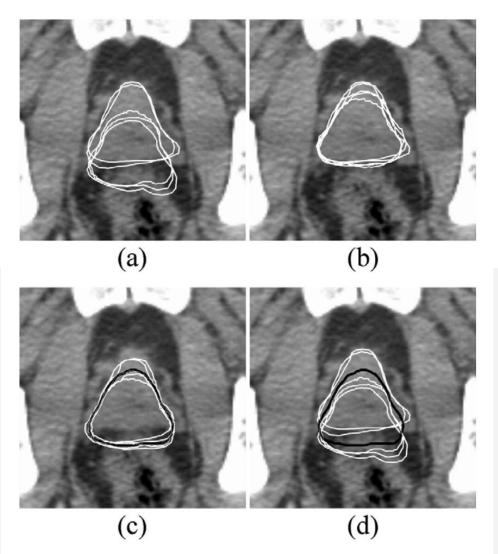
Construction of the average prostate shape and position (planning computed tomography [pCT] scan, axial view). (a) Prostates of the *first 5 scans* resampled on the planning CT scan after bone matching; (b) prostates matched to the prostate of the planning CT scan; (c) prostates moved to the average position and calculated average prostate shape (black line); (d) prostates of the *first 5 scans* after bone matching, and average prostate (black line).
